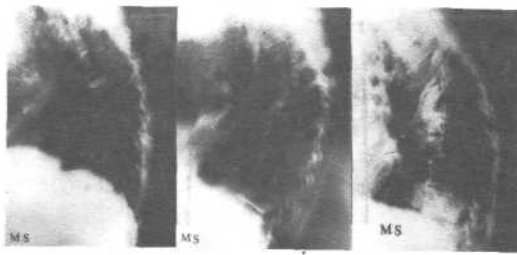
M.S., female, 53 years old, vascular pedicular rib graft, good and fast solid union after 16 weeks postop. x-ray 3 1/2 years after operation.
